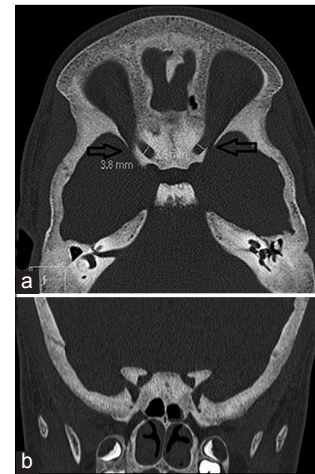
Axial and coronal CT scan brain images show an abnormally increased density of all the skull bones with narrowing of bilateral optic canal (white arrows)
